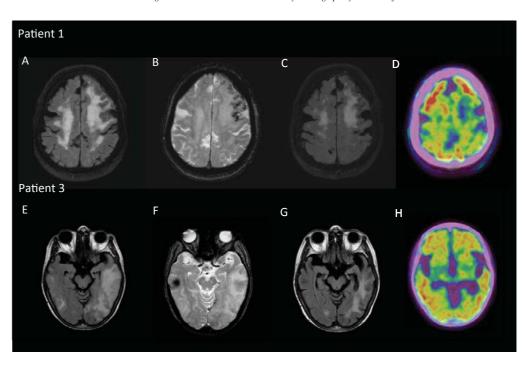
Neuroimaging findings in 2 patients with CAA-ri. Neuroimaging findings in patient 1 (A–D) and patient 3 (E–H). A) Magnetic resonance imaging (MRI) demonstrating subcortical asymmetric white matter lesions affecting predominantly left frontal lobe on a fluid-attenuated inversion recovery sequence (FLAIR) sequences. B) MRI T2*-GRE weighted sequences showing extensive lobar microbleeds that colocalized with the area of the edema. C) FLAIR sequence MRI performed two months after corticosteroid treatment, showing reduction of cerebral edema. D) PET imaging with Florbetapir showing retention of the amyloid tracer in frontal and parietal regions. Note the swollen region, where PET shows a lower Florbetapir uptake (SUVr = 1.08 in left frontal inferior gyrus, SUVr = 1.05 in left precentral gyrus, SUVr = 1.08 in left postcentral gyrus) than in the homonym contralateral areas (SUVr = 1.10 in right frontal inferior gyrus, SUVr = 1.06 in right precentral gyrus, SUVr = 1.18 in right postcentral gyrus). E) MRI performed to patient 3, showing subcortical asymmetric white matter lesions affecting left temporal occipital lobes on FLAIR sequence. F) MRI T2*-GRE weighted sequences indicating the presence of lobar microbleeds on the affected areas (arrows). G) One month after corticosteroid treatment the FLAIR MRI image showed reduction of the white matter lesions. H) PET imaging with Florbetapir shows cortical retention of the amyloid tracer. Note the swollen region, where the Florbetapir uptake (SUVr = 1.85 in left temporal middle gyrus, SUVr = 1.89 in right temporal middle gyrus) is lower than in homonym contralateral regions (SUVr = 1.98 in right temporal middle gyrus, SUVr = 1.97 in right occipital middle gyrus) is
